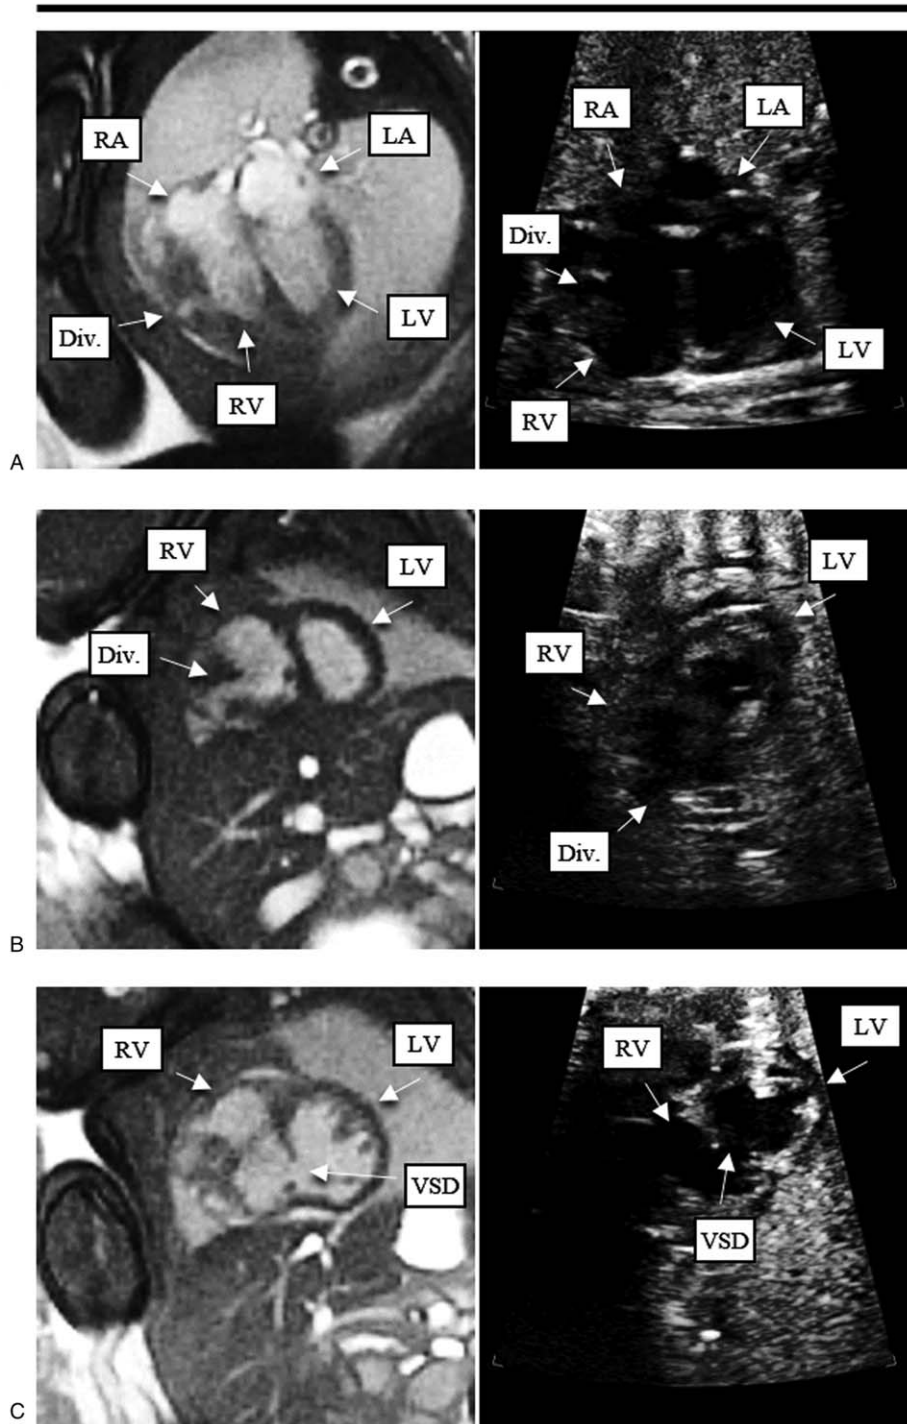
A 36-week fetus with a septal defect and diverticulum. Fetal cardiac MRI (left) and echocardiography (right) images demonstrate a diverticulum (Div.) attached to the right ventricle (RV) in long-axis (A) and short-axis views (B), and an interruption of the myocardium indicates a ventricular septal defect (VSD) in a short-axis view (C). Reprinted with permission from *Circ Cardiovasc Imaging* 2018; 11:e007745 used under CC BY.
